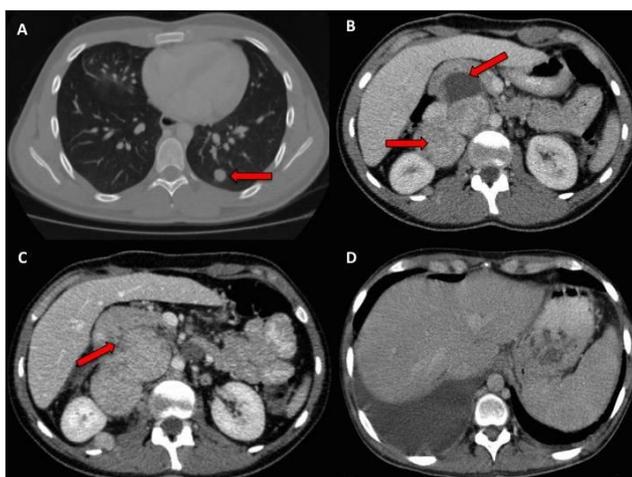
Thoracic and abdominal computed tomography (CT) scan images. Panel (A) and (B) axial images from November 2008. They show a relapse with 2 solid nodules in left lung and a heterogeneous retroperitoneal mass. Panel (C) axial image from April 2009. It shows a partial response with a reduction in size of the retroperitoneal
